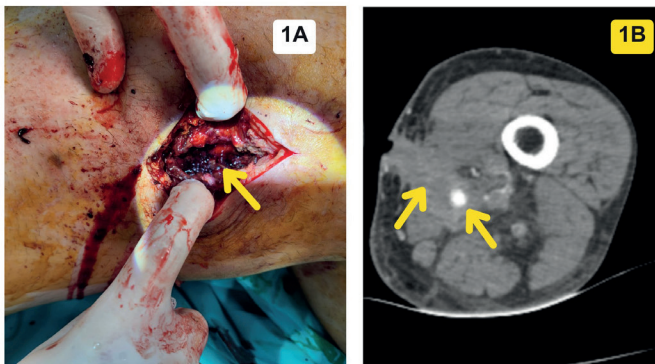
A. CT angiographic image of infected tissue, B. Hematoma at supra-geneal region
